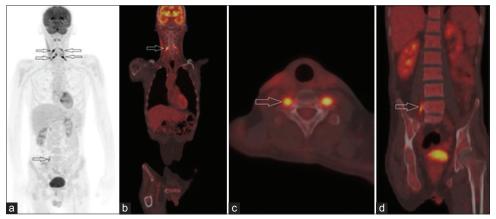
Positron emission tomography/computed tomography (PET/CT) maximum intensity projection (MIP) image (a) shows involvement of cervical and lumbar spinal nerve roots (arrows). Arrows indicate 18F-fluorodeoxyglucose (FDG) uptake by cervical nerve root on coronal fusion image (b), by the nerve root of C7 on axial fusion image (c), by the nerve root of L4 on coronal fusion image (d)
